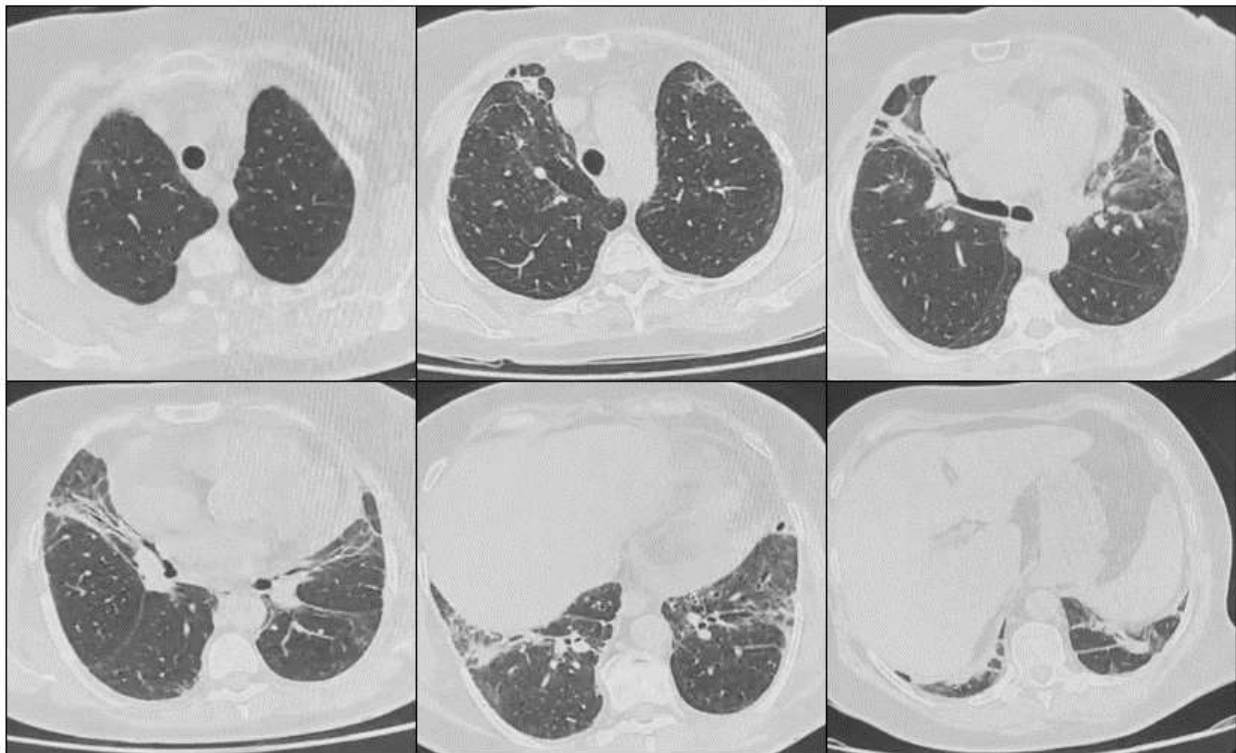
Initial high-resolution chest computed tomography showing bilateral cylindrical bronchiectasis and a fibrotic nonspecific interstitial pneumonia pattern, with ground-glass opacities, septal and non-septal thickening, subpleural reticulations, traction bronchiectasis and architectural distortion, associated with moderate pericardial effusion.
